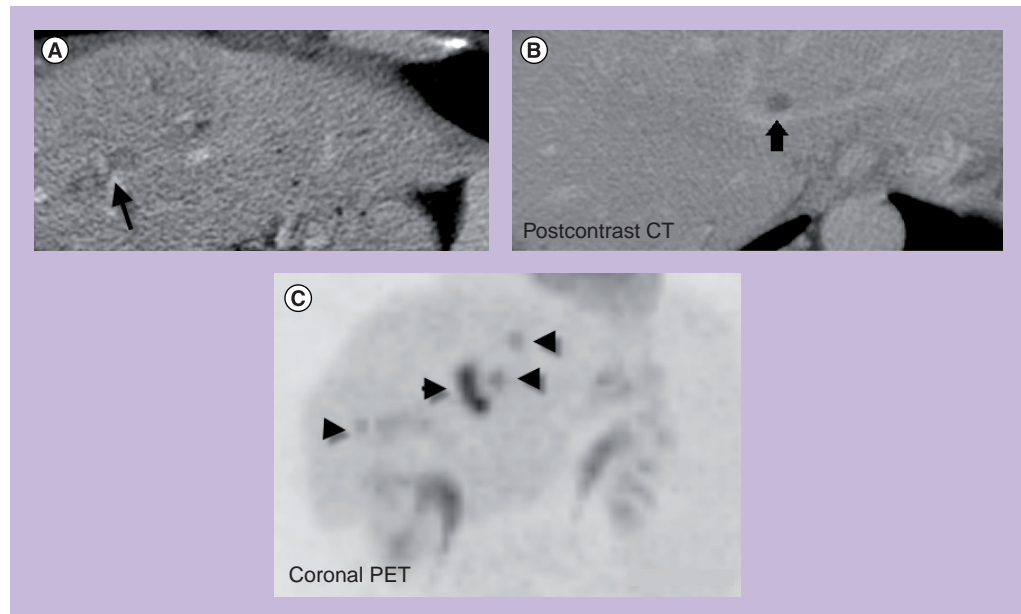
Proper preprocedural workup is essential. Traditional metastatic workup with contrast-enhanced CT demonstrates two metastatic lesions (A & B) (black arrows). PET/CT demonstrated additional lesions (black arrowheads), making the patient no longer a candidate for radiofrequency ablation (C).
